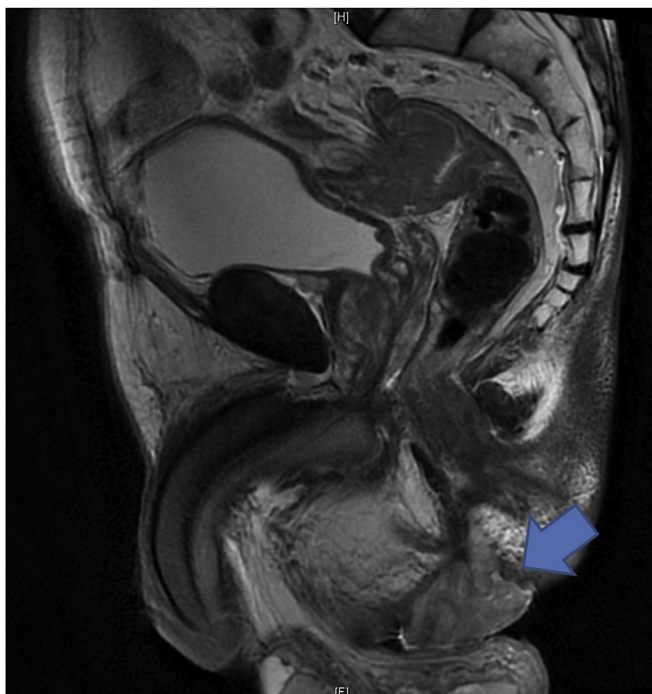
Perineal lump as visualised on MRI (Arrow).
